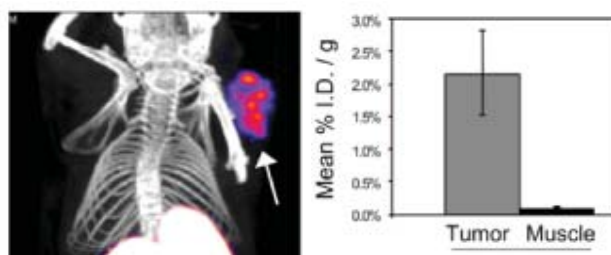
NanoSPECT/CT image of a breast cancer xenograft using <sup>111</sup>Indium-A20FMDV2 (left panel) and calculated % injected dose per gram of tissue for tumour versus muscle (right panel)
